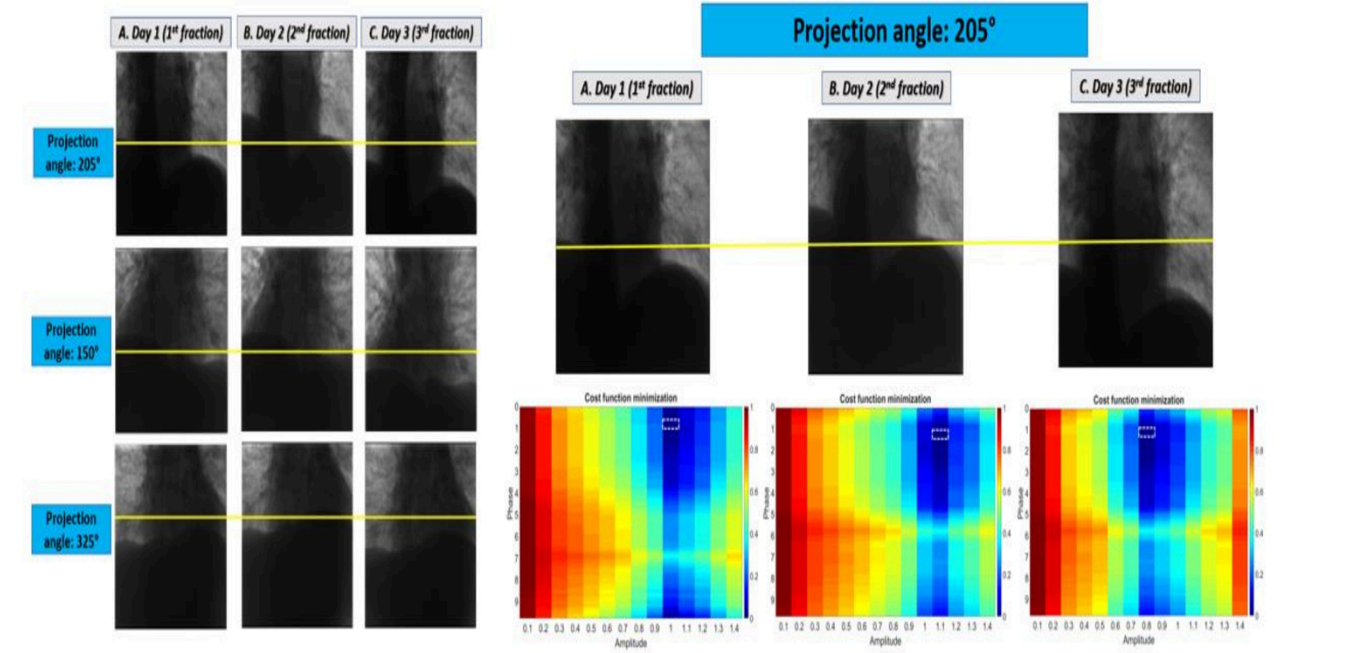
Radiograph images at different projection angles and fractions during treatment. Best matched parameters were determined by comparison between DRR database and radiograph
